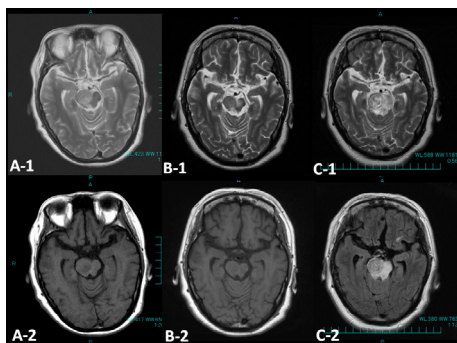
Follow-up MRI of case 2. A-1, 2: After 6 months. B-1, 2: After 36 months. C-1, 2: After 42 months. The tumor in the brainstem is smaller than before, and stable for almost 4 years.
